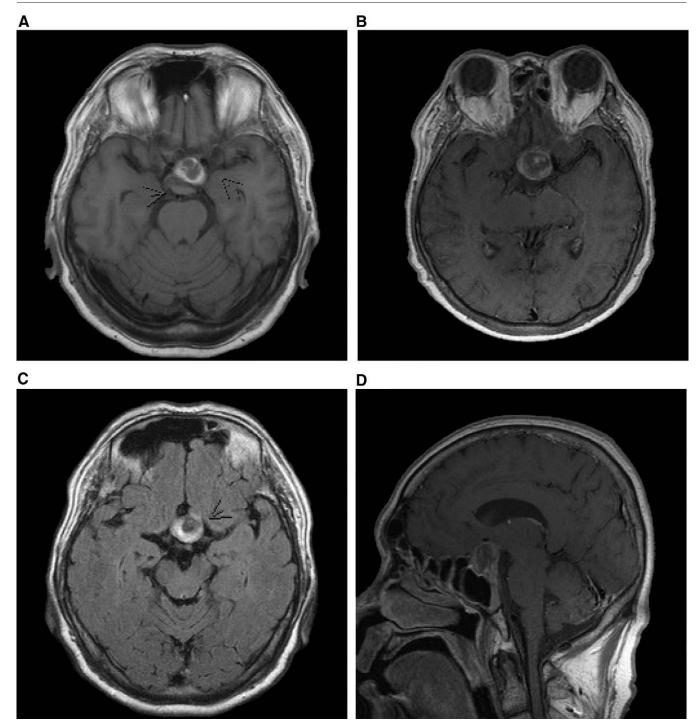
Brain MRI of this patient. A, Axial view of T1WI. B, Axial view of T1WI with contrast injection. C, Axial view of fluid-attenuated inversion recovery (FLAIR). D, Sagittal view of T1WI with contrast injection.
